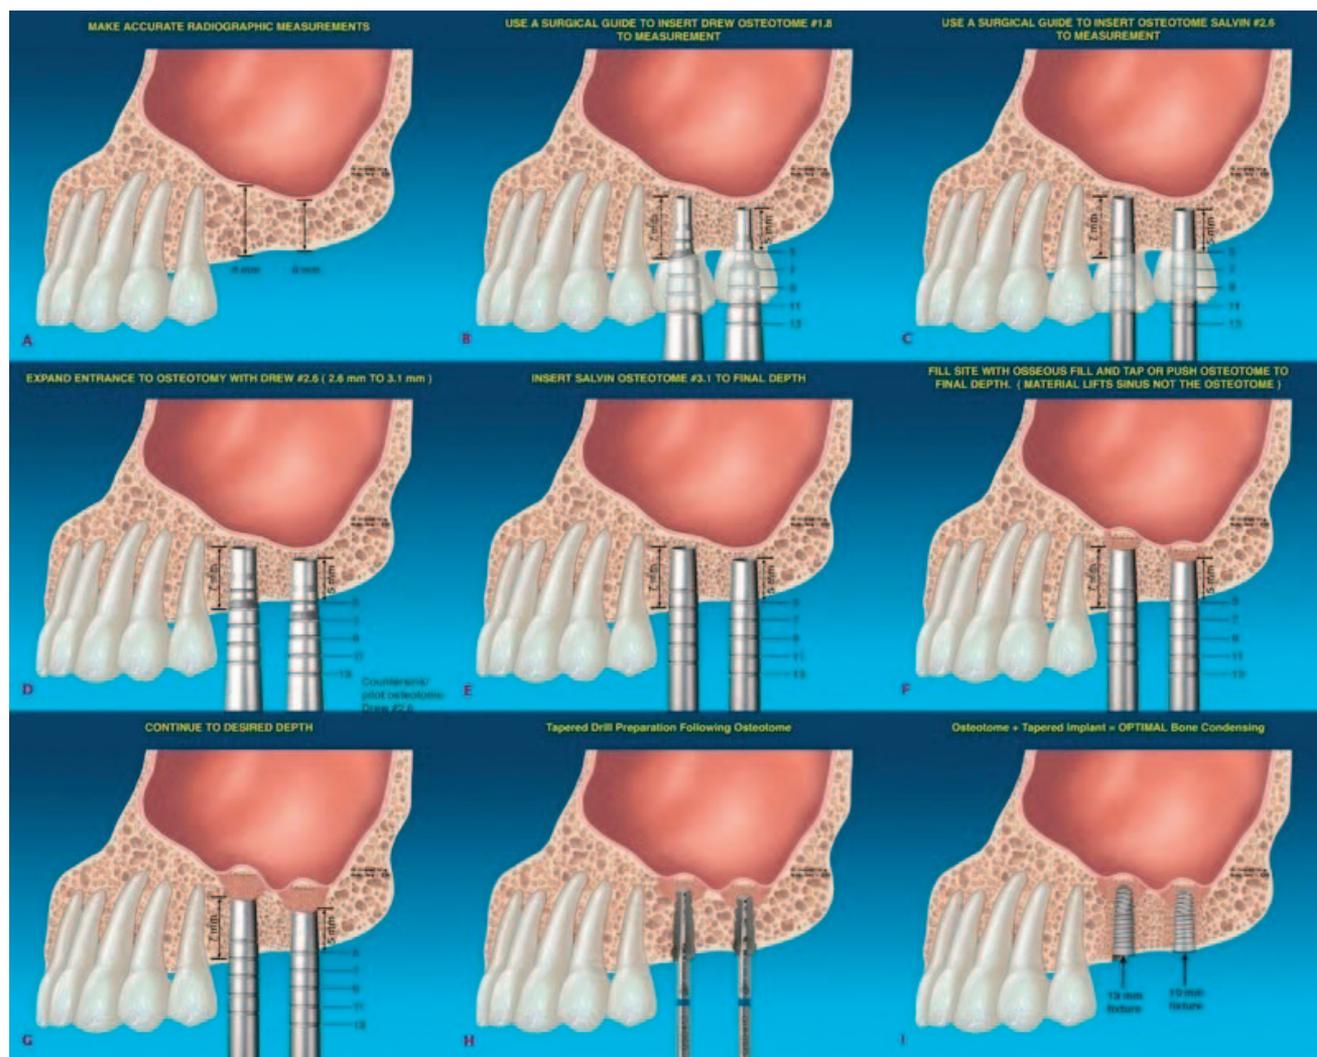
A combination of divergent and intermediary osteotomes is used to prepare the osteotomy during crestal sinus floor elevation. A surgical stent is used to mark the proposed osteotomies. Radiographic measurements are taken from the osseous crest to the floor of the sinus, and the osteotomies are prepared 1 mm short of the sinus floor to allow the bone graft to lift the floor of the sinus. The final shaping drill is used primarily in virgin bone before placing the tapered implant fixture.
